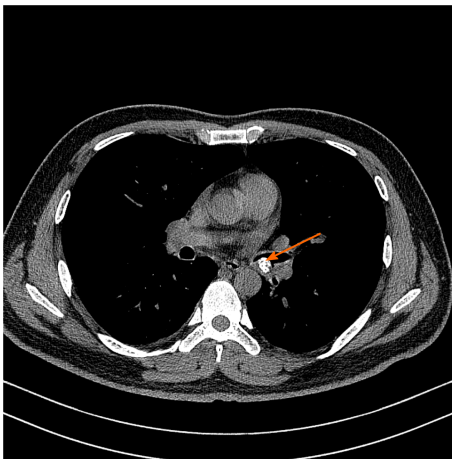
Chest computed tomography. A 1.20 cm × 0.88 cm calcified nodular lesion on the compressed posterior wall of the lower left main bronchus (orange arrow).
